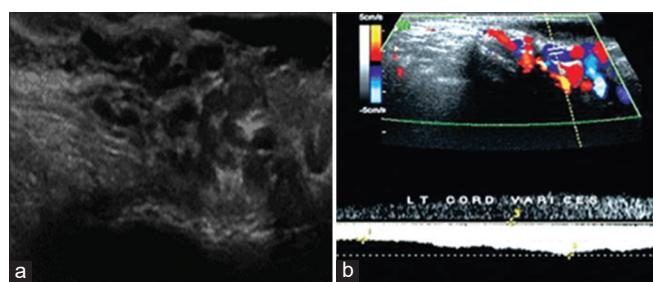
(a and b) shows case of varicocele with color and spectral Doppler findings
